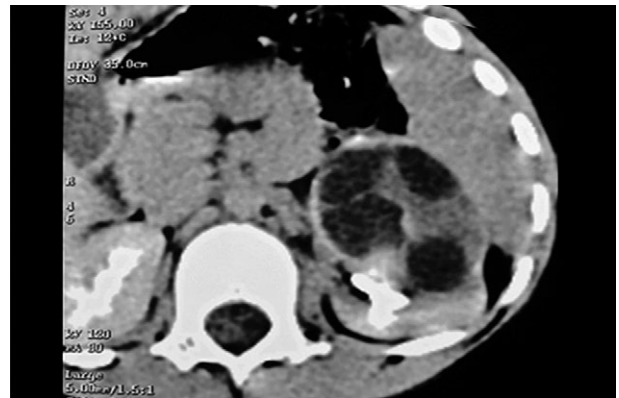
Left renal hydatid cyst. Another 9-year-old boy presented with left flank pain. A hydatid cyst of the left kidney type III of Gharbi's classification was identified: axial contrast CT image shows a well-defined complex cystic mass within the left renal parenchyma. The mass contains multiple smaller cysts with variable but predominantly low attenuation fluid matrix.
